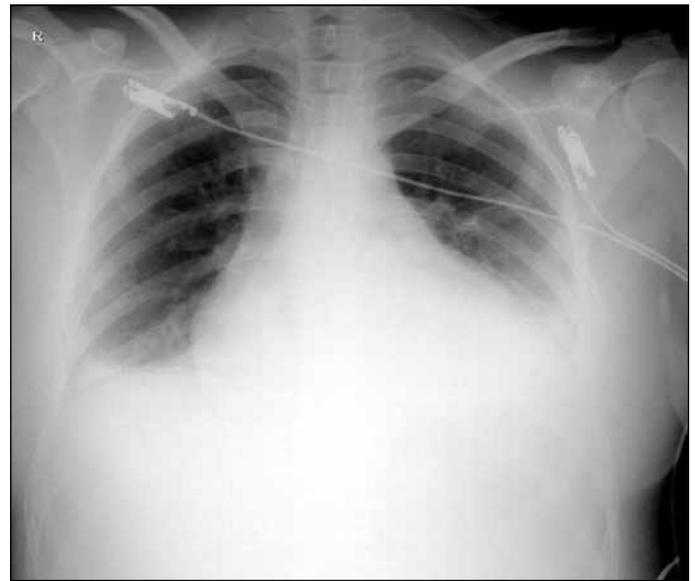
Opacity in the chest radiography, consistent with pleural fluid on the left extending to the middle zone.
